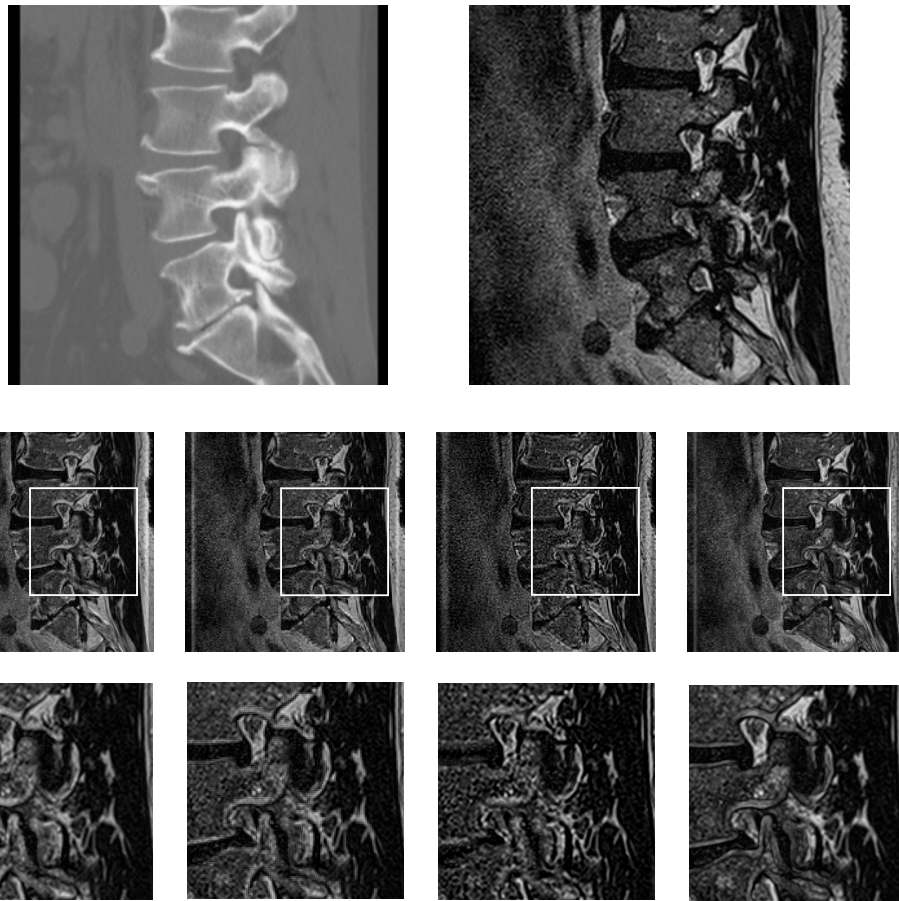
Sample fused Images: top left - input CT, top right input MR, middle: fused images from left to right, averaging method, discrete wavelet transform, contourlet, graph cut methods, bottom: close ups of the images.
